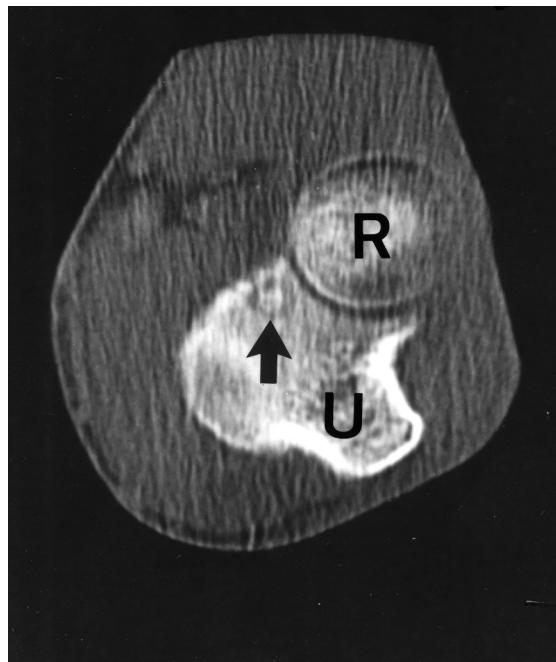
CT of the left elbow (axial view). A 5 mm lucent area suggesting the tumor nidus (arrow) is located at the coronoid process. U: ulna, R: radial head.
